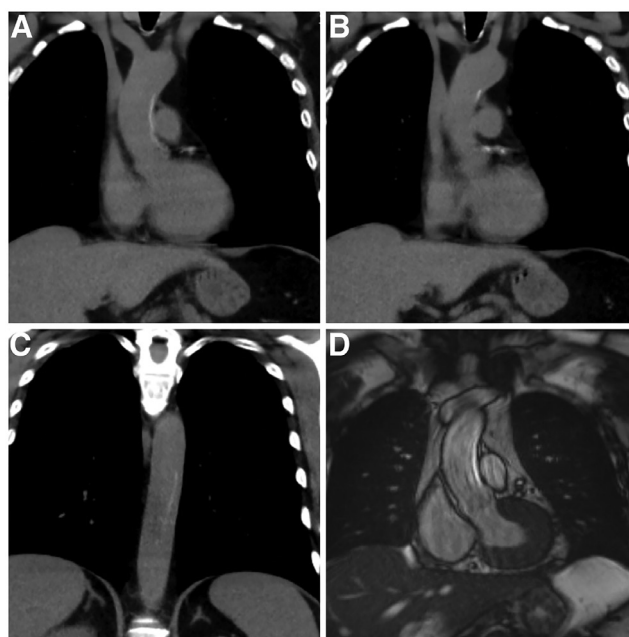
Multimodality imaging of angiographically occult retained guidewire. (A-C) Contrast-enhanced thoracic computed tomography demonstrating a long linear intravascular structure extending from the left main coronary artery (LMCA) through the ascending and descending thoracic aorta. (D) Cardiac magnetic resonance imaging showing a linear signal void within the aortic lumen, consistent with a retained intravascular guidewire
